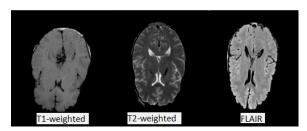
Axial images of T1-weighted, T2-weighted, and FLAIR MRI
